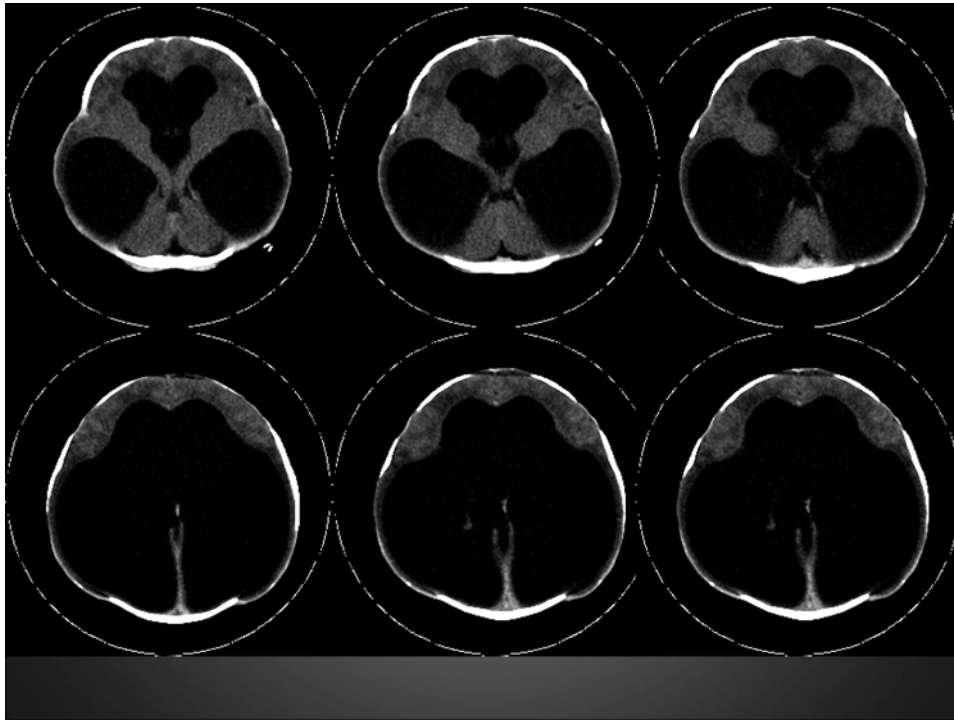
MRI images of a child with hydrocephalus
